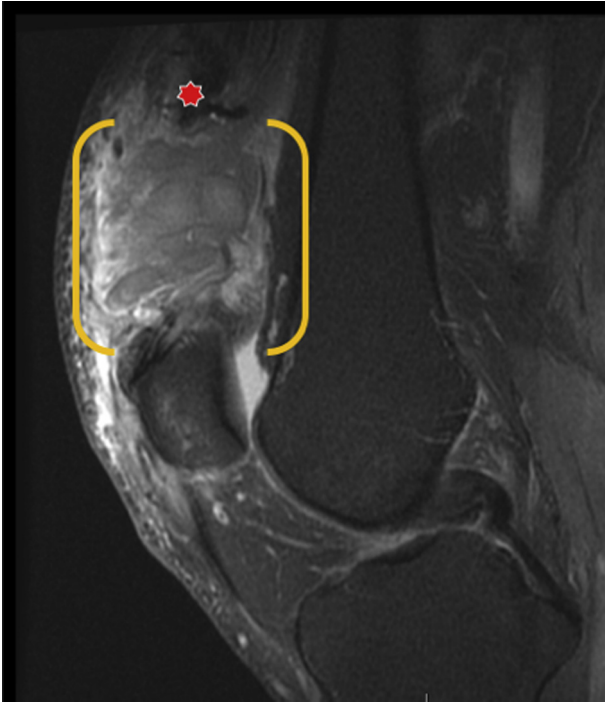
Preoperative Sagittal T2 magnetic resonance imaging scan showing chronic quadriceps tendon tear with proximal retraction of the tendon (star) and defect present (brackets).
